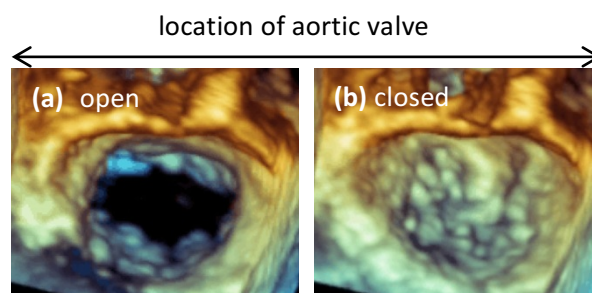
3D echocardiogram of a healthy mitral valve (a) more circular in diastole (blood flow into the page) (b) more kidney-shaped in systole (acknowledgements: Pantazis A, The Heart Hospital, London).
